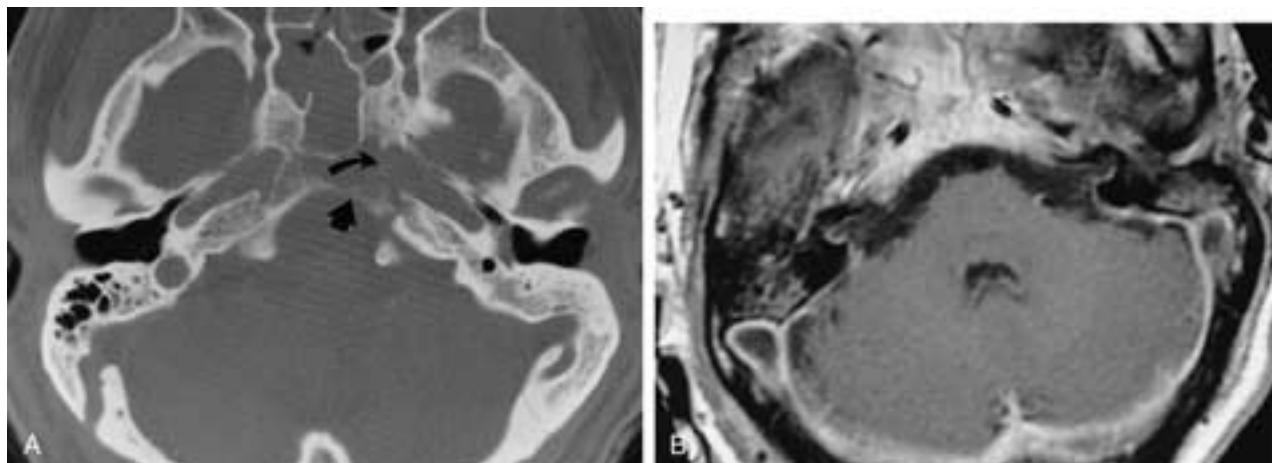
Skull base osteomyelitis secondary to sphenoid sinusitis. A, Axial CT image. There is opacification of the sphenoid sinus, thinning of the posterior wall of the sinus, and destruction of the clivus (arrow) and the petrous apex, with erosion extending into the internal carotid artery canal (curved arrow). B, T1-weighted axial postcontrast MR image shows enhancement of the clivus, petrous apices, and diffuse dural enhancement extending into the IACs.
